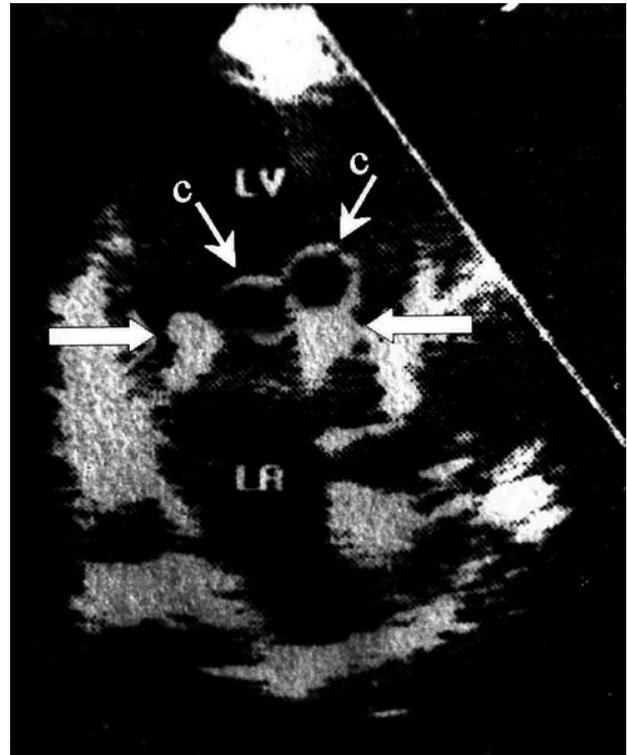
Echocardiography showing a pseudoparachute-like formation associated with multiple cysts attached to the anterior mitral leaflet leading to floppy mitral valve syndrome and severe mitral regurgitation. LV: Left ventricle; LA: Left atrium; C: cysts (arrows).
